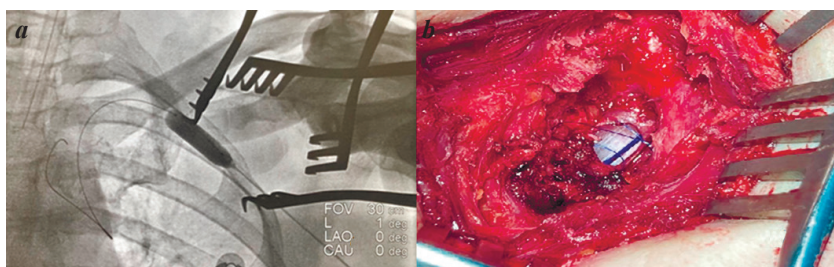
Balloon catheter inflated in the left subclavian vein: a) chest radiograph, b) photograph of the surgical phase.
